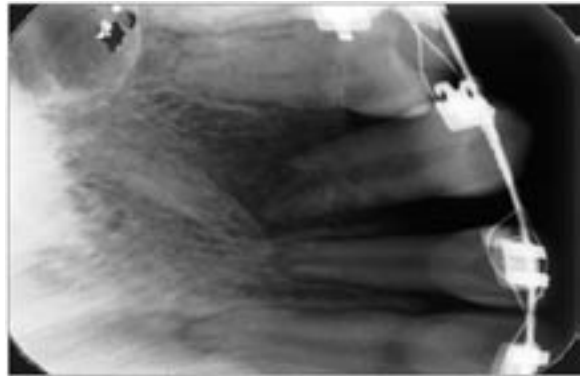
Panoramic radiograms and radiogram of a 14.5-year-old girl with distinct advanced tooth resorption 12, 22
